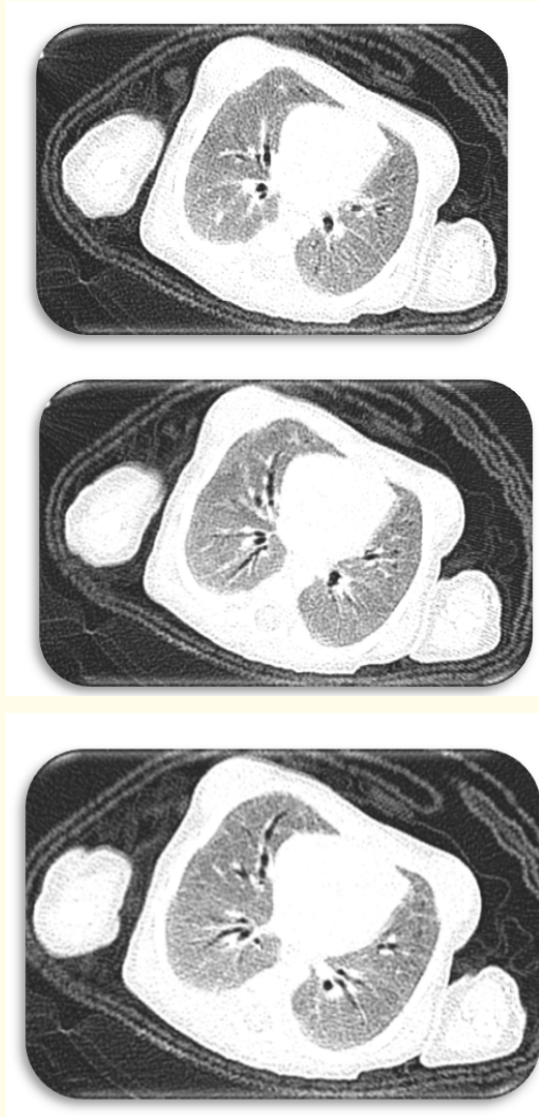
Chest CT showed diffuse bilateral ground glass opacities, bilateral diffuse dilated bronchi and bronchiole, and interlobular septal thickening.
